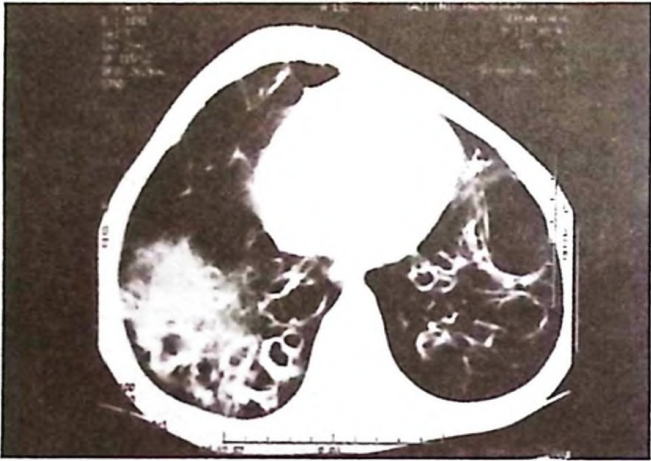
Thoracal computed tomography (CT) scan in 1995 demonstrated newly developing cystic bronchiectasis affecting both the lower lobes and the middle lobe. The bronchiectasis was more severe in the left paracardiac region (arrow).
